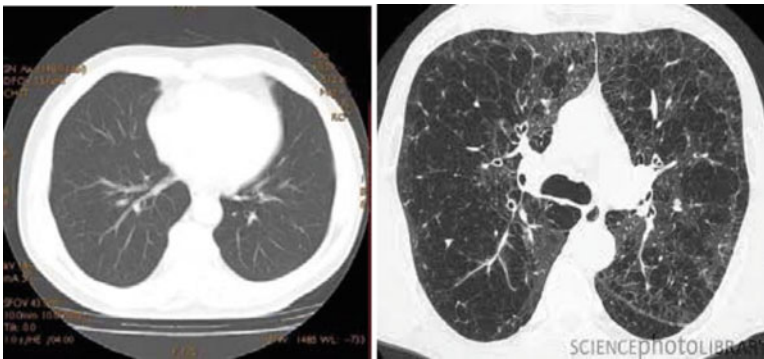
Left: CT scan of lung with normal parenchyma. Right: CT scan of lung with emphysema
